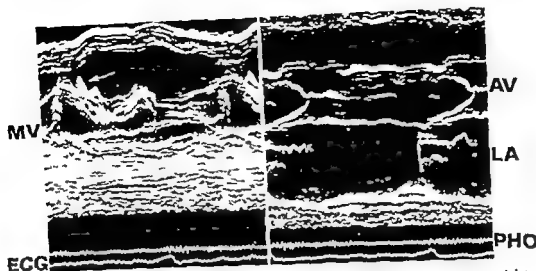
Left Mitral valve echocardiogram from Case 2. There are shaggy echoes and coarse diastolic undulations (arrow) consistent with bacterial vegetations and chordae rupture. Systolic flutter is not seen. Other records showed classical mitral valve prolapse. Right Aortic root echocardiogram. Coarse and fine flutter of prolapsing mitral elements are recorded in systole within the left atrial cavity. These findings were absent prior to bacterial endocarditis.
